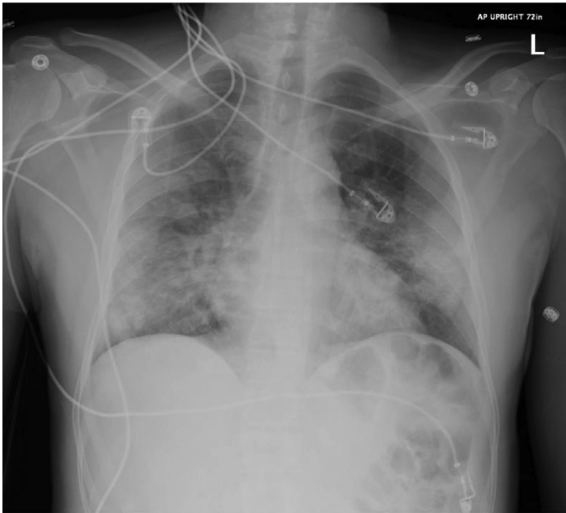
Chest X-Ray on admission: Multifocal pulmonary consolidative opacities are present.
